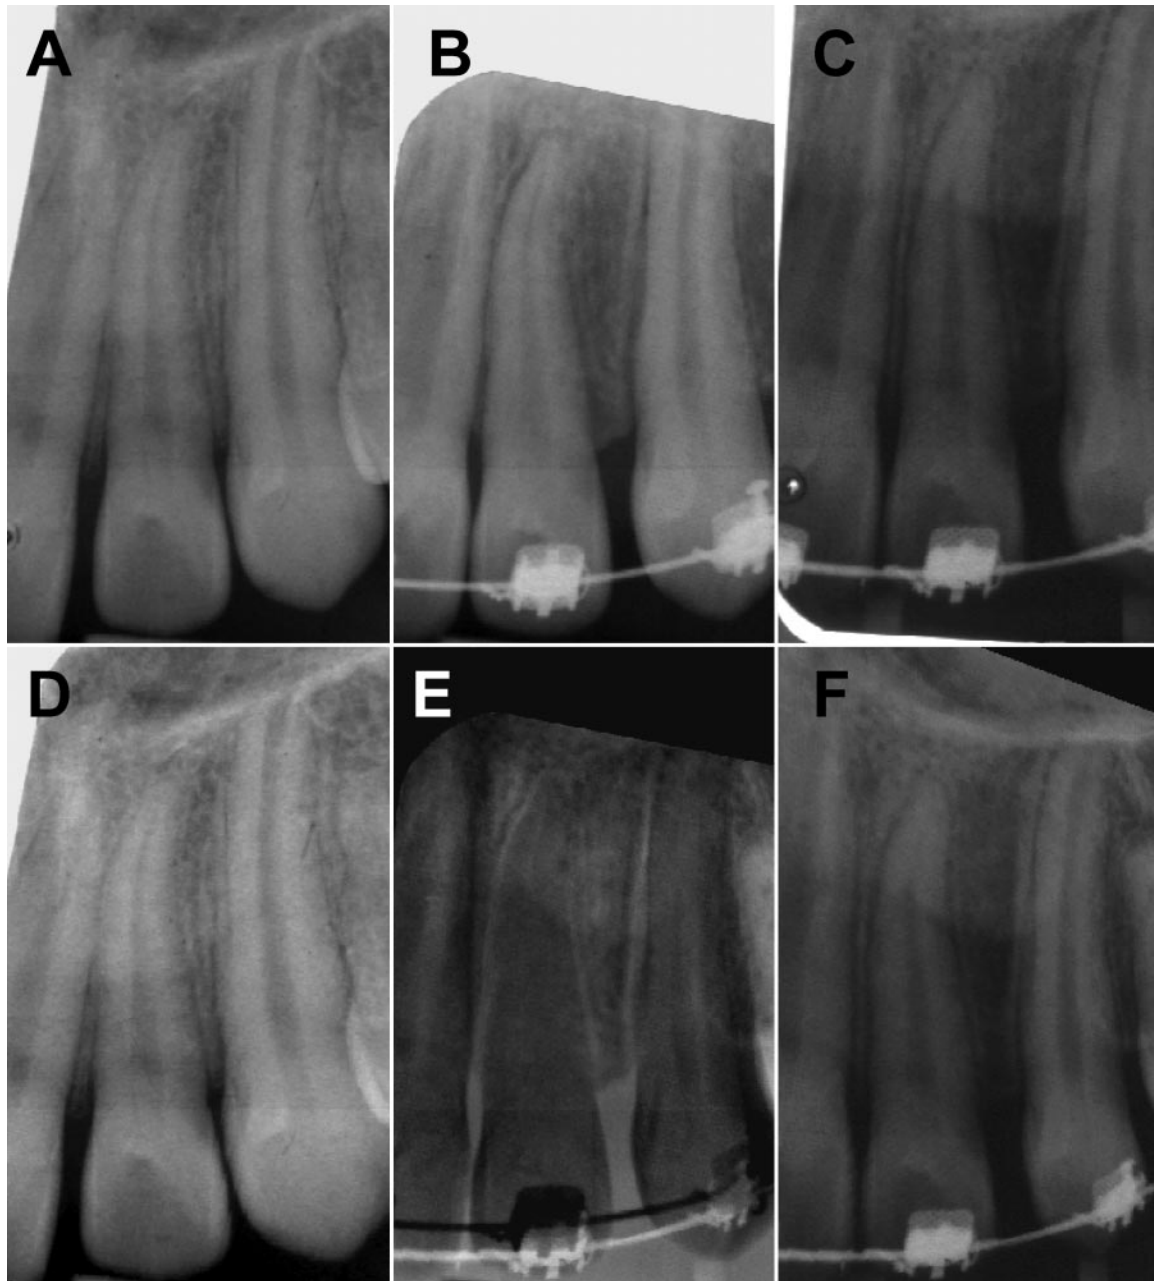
Reconstruction of pretreatment (T1) and 12-month follow-up periapical radiographs (T3) according to radiographic projection at six-month follow-up (T2): (A) original T1 image; (B) original T2 image; (C) original T3 image; (D) reconstructed T1 image; (E) subtraction of reconstructed T3 image from original T2 image; (F) reconstructed T3 image.
